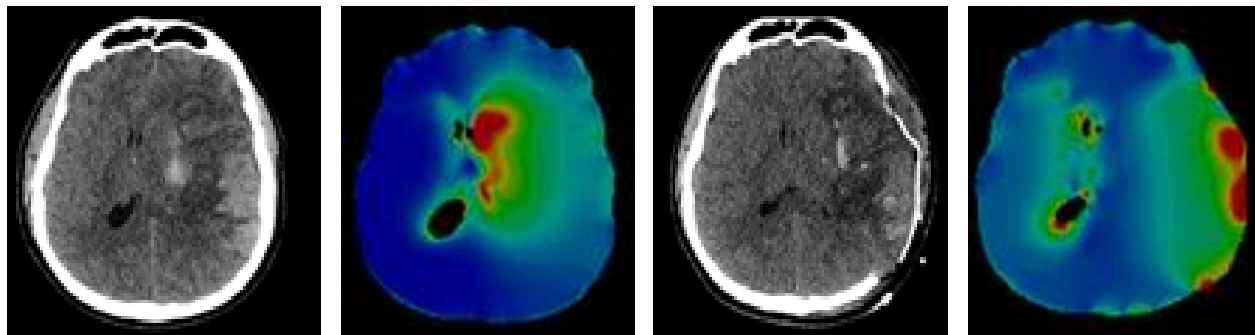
Evaluation of strain level in different anatomical areas in the brain tissue before (left black image with CT, left colour image with NIBIE) and after the decompressive hemicraniectomy (right black image with CT, right colour image with NIBIE).
